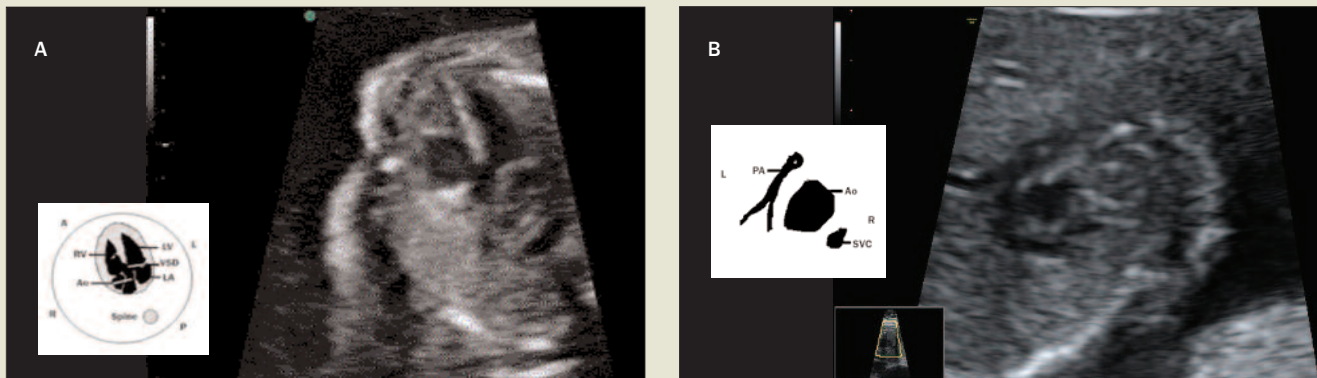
Fetal echocardiogram showing the intrauterine features of tetralogy of Fallot at 20 weeks' gestation. a (left). Five-chamber view showing large malalignment ventricular septal defect (VSD) with overriding aorta (Ao). b (right). Three-vessel view showing the small pulmonary artery (PA), wide aorta (Ao) and superior vena cava (SVC). Right ventricular hypertrophy is not a feature of in utero tetralogy of Fallot. A = anterior; L = left; LA = left atrium; LV = left ventricle; P = posterior; R = right; RV = right ventricle.
